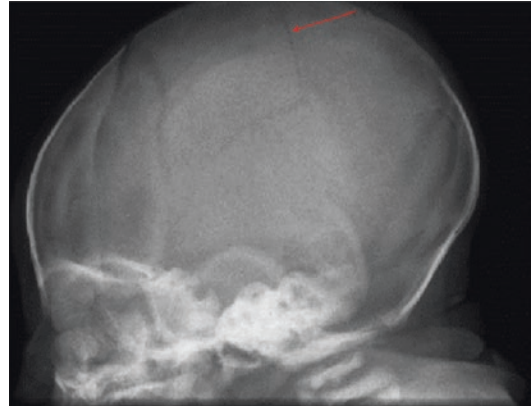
Skull X-ray lateral view of infant with linear skull fracture (arrows)
